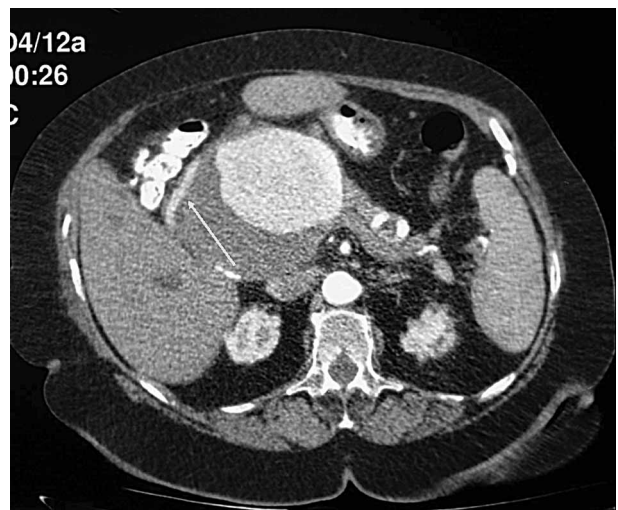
Patient 5: Contrast enhanced CT demonstrates a large, thrombus containing pseudoaneurysm of the right hepatic artery. The feeding artery is coursing along the lateral aspect, entering the pseudoaneurysm anteriorly (arrow).
